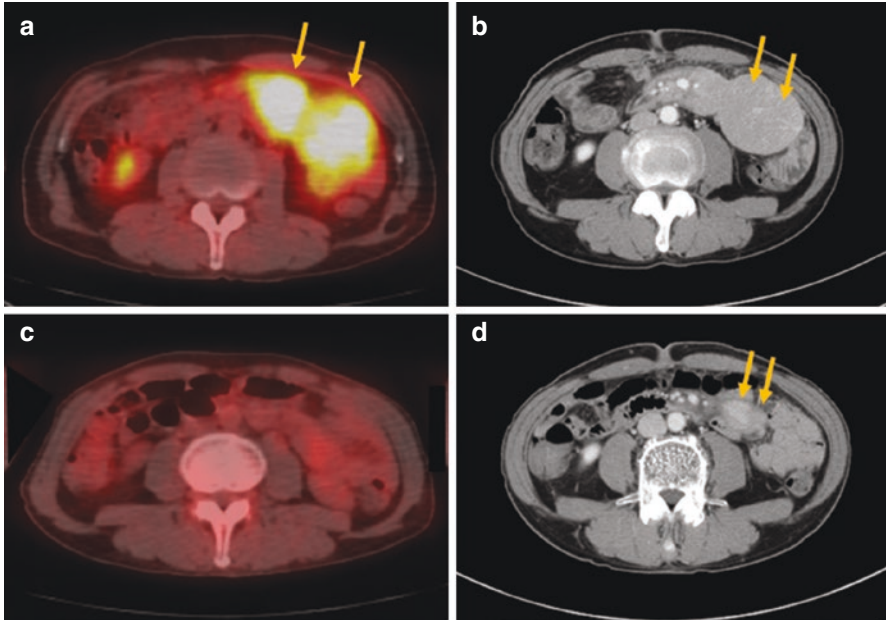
Pretreatment and posttreatment images in a patient with follicular lymphoma. Pretreatment PET/CT (a) and CT scan (b) shows large mesenteric lymph nodes (arrows). Posttreatment PET/CT (c) demonstrates no uptake of FDG, but residual mass on CT scan (arrows) (d)
